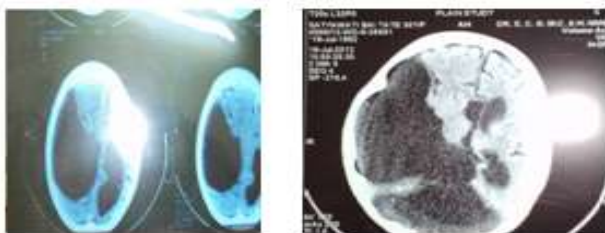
CT Images of Brain Showing Large Open Cleft Schizencephaly
